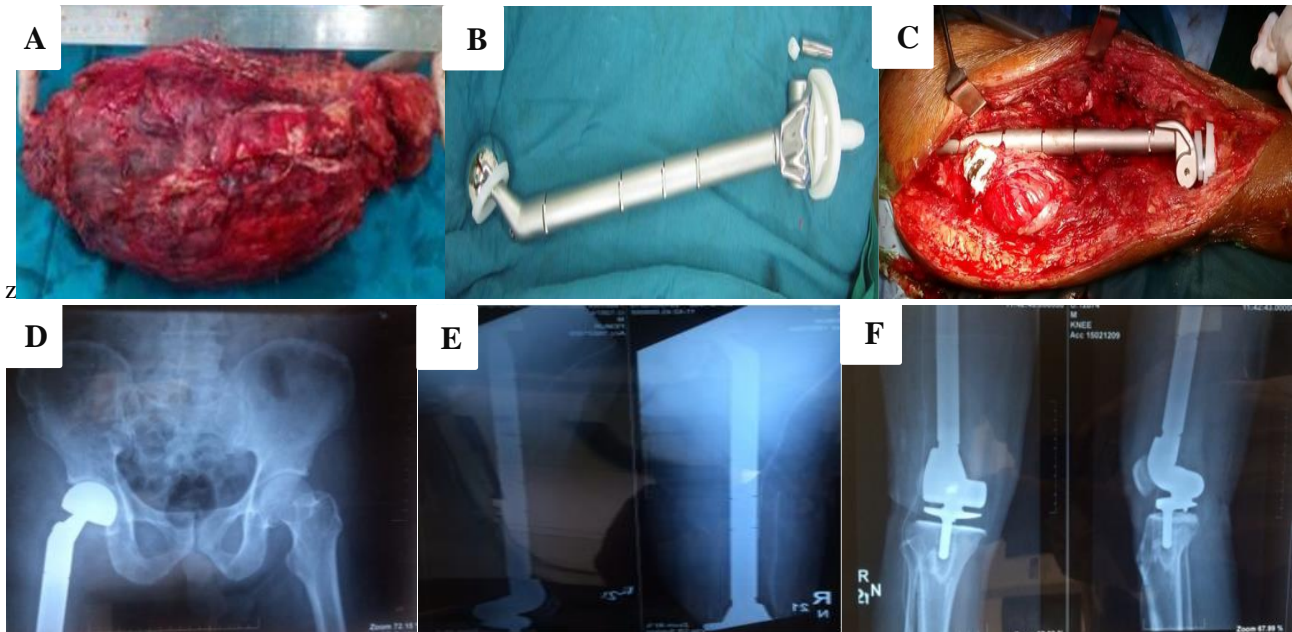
Total femoral replacement with cemented modular prosthesis following wide excision of the tumor. (A): clinical picture of the tumor, (B): a customized total femoral prosthesis, (C): a customized, titanium total femoral prosthesis was then inserted, (D): pelvic X-ray AP view post-operative insertion of bipolar, (E): femur X-ray AP/Lateral view post-operative insertion of femoral prosthesis, (F): knee X-ray AP/Lateral view post-operative insertion of femoral prosthesis.
